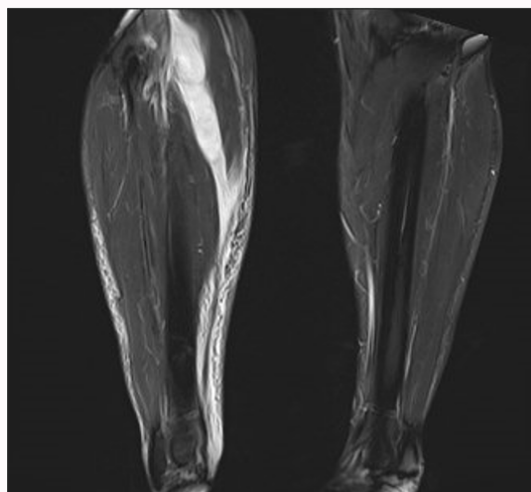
Lower extremity MRI, T2 sequence.
